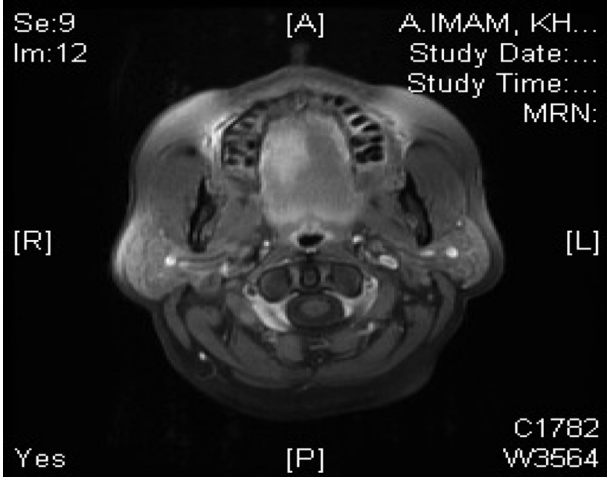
T2 weighted magnetic resonance imaging showing intramuscular haemangioma of the tongue. In the image it is seen as a triangular hyperechoic lesion as compared with the surrounding hypoechoic tongue tissue. The lesion shows fluid content without any solid component (hyperechoic on T2 imaging).
